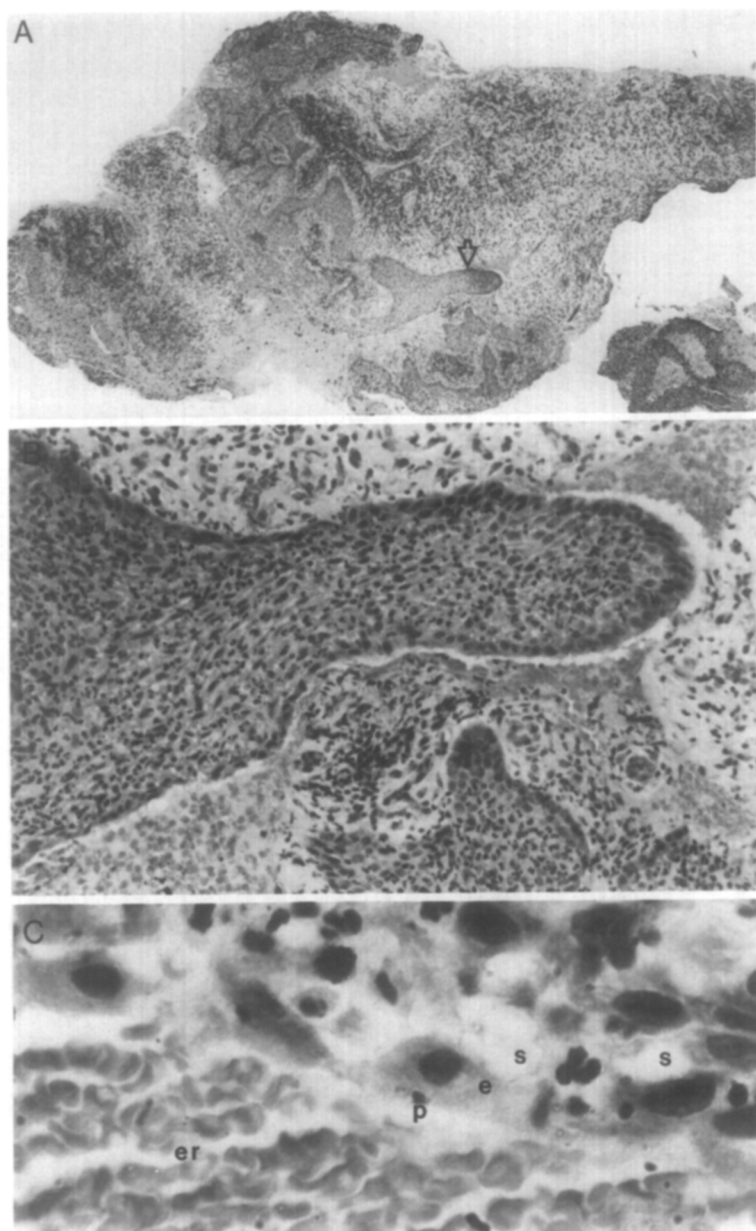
Case 248. Teeth 7 and 8 (Fig. 9) presented with a history of trauma in which the teeth were displaced lingually and repositioned several years previously. At the time of endodontic intervention there was moderate swelling but no pain. There was a 4 mm. apical area radiographically. At the initial appointment both teeth were débrided and totally instrumented, and 4 days later they were filled with gutta-percha. Three days after obturation, curettage was performed on both teeth, and an apical amalgam was placed on No. 8. A 4-year clinical and radiographic follow-up indicated healing of periapical tissue of tooth 8, and a considerable reduction of the size of the lesion above tooth 7. *A*, Conspicuous epithelial sheaths and disintegrating blood. *B*, From area indicated by arrow in *A*. Fingerlike epithelial projection with numerous neutrophilic leukocytes and adjacent extravasated blood. *C*, Neutrophilic leukocytes adjacent to empty spaces (*s*), degenerating epithelial cell (*e*), and extravasated erythrocytes (*er*) with small particles of brown pigment (*p*). (Magnifications: *A*, $\times 32$; *B*, $\times 400$; *C*, $\times 1,000$.)
